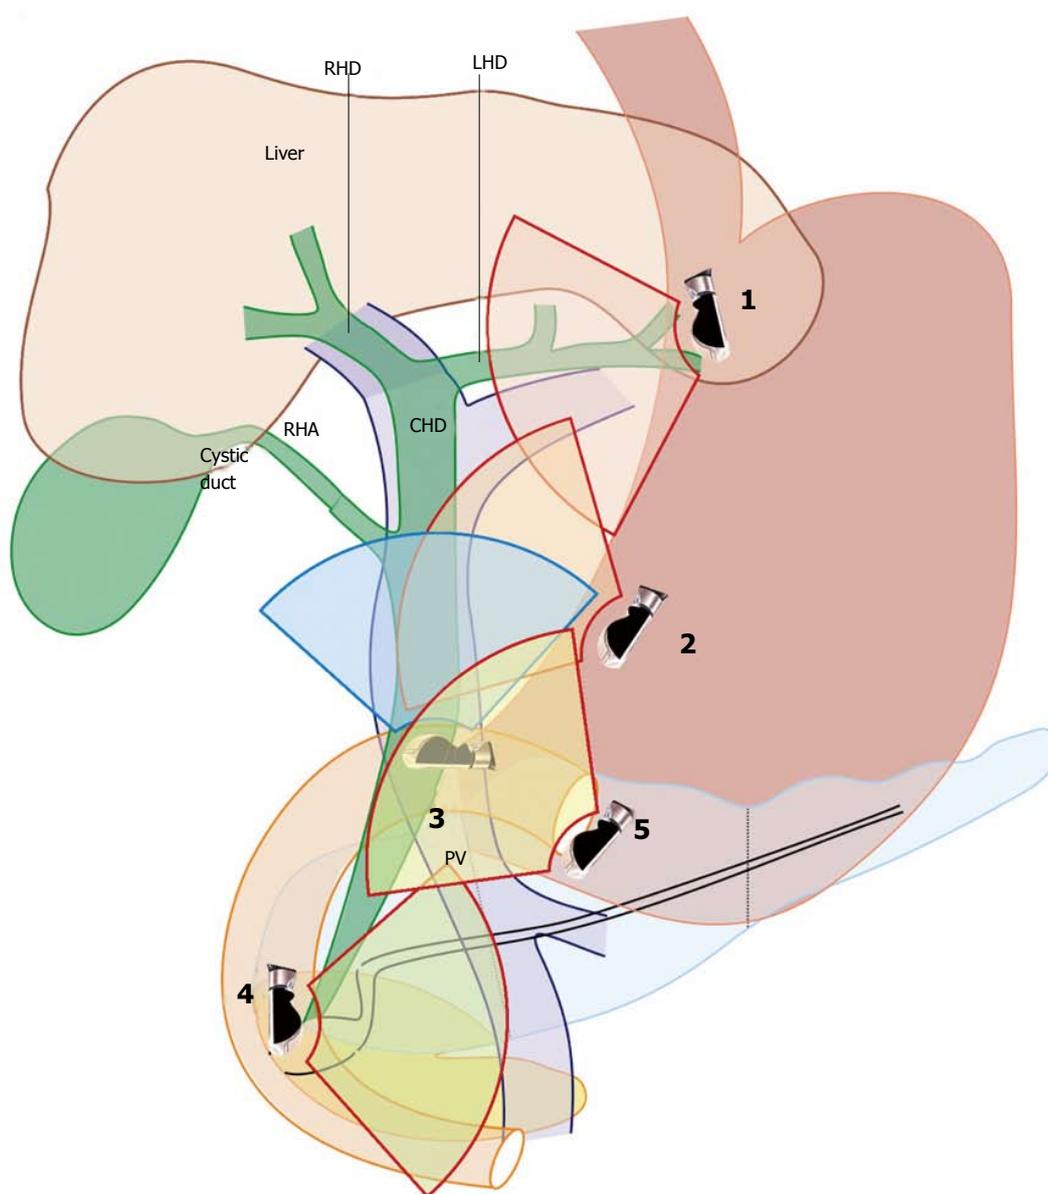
Five positions of Common bile duct imaging by endoscopic ultrasound are shown. CHD: Common hepatic duct; RHA: Right hepatic artery; RHD: Right hepatic duct; LHD: Left Hepatic duct.
